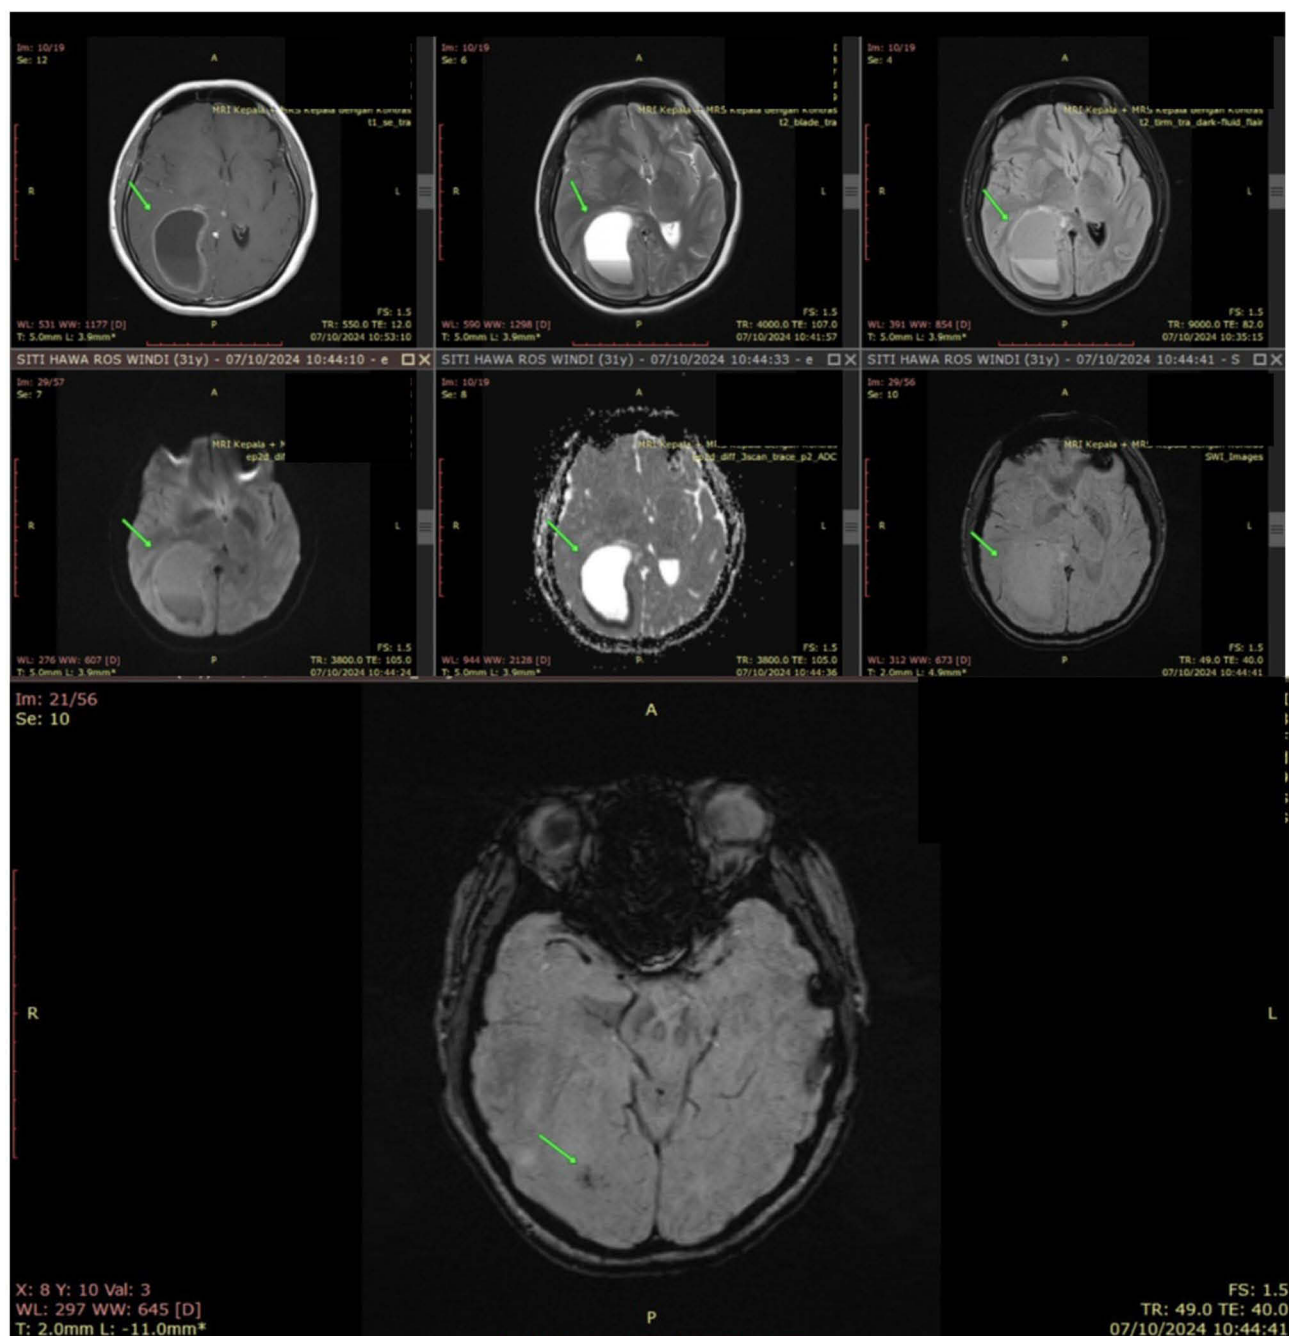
Axial MRI of the brain demonstrating multiple inhomogeneous solid masses within the right temporoparietal lobe, marked by irregular borders, central necrosis, and hemorrhagic components. Surrounding vasogenic edema significantly compresses the adjacent sulci, right Sylvian fissure, lateral ventricles, and deep brain structures, producing a mild leftward midline shift. Lesions exhibit hypointense T1-weighted signal intensity and hyperintense T2-weighted and T2-FLAIR signals with restricted diffusion and susceptibility artifacts. Post-contrast imaging revealed irregular rim enhancement, consistent with metastatic deposits. Orientation markers: A = anterior; P = posterior; H = head (superior); F = foot (inferior); AF = anterior foot; PF = posterior foot; RFP = right foot posterior; LHA = left head anterior; PH = posterior head.
